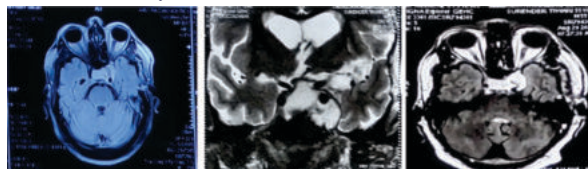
Post Operative MRI Image
